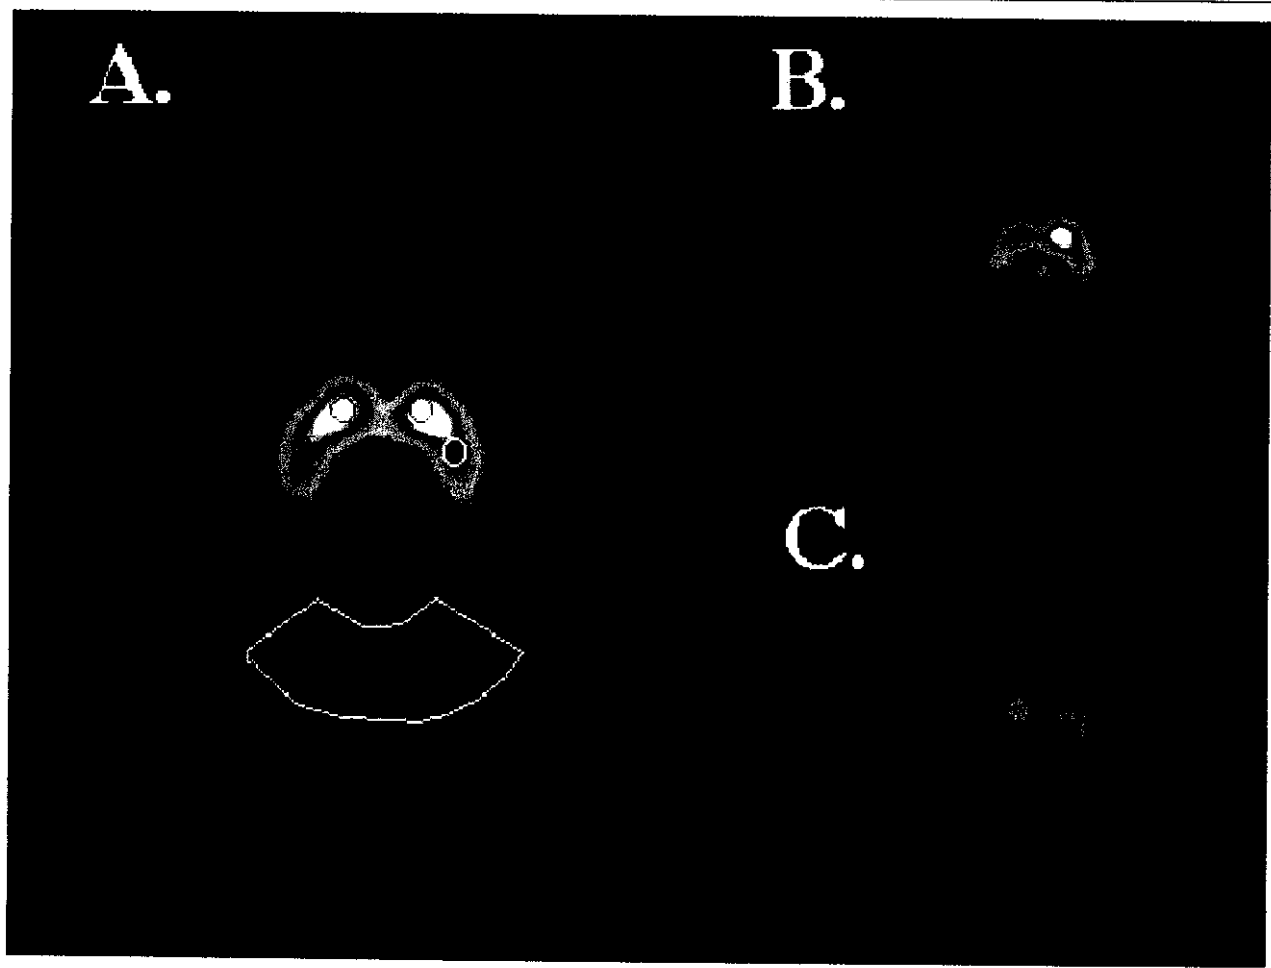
Transaxial single-photon emission computed tomographic images at the level of striatum in healthy control (A) and idiopathic Parkinson's disease subject Hoehn-Yahr stage 1 (B) and stage 4 (C) obtained at 24 hours following the injection of  $(^{123}\text{I})\beta\text{-CIT}$ . The healthy subject scan demonstrates regions of interest placed in right and left caudate and putamen and occipital cortex.
